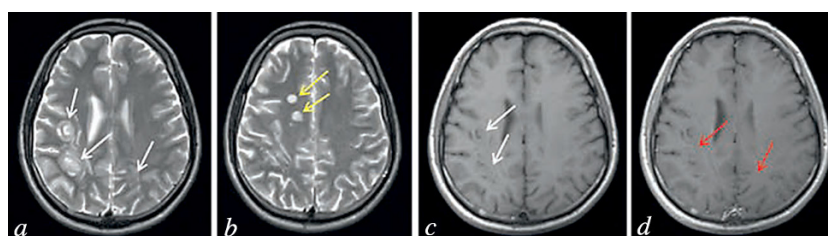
Brain MRI scan with contrast, March 21, 2016, T2 (a, b), T1 (c), and T1 modes after administration of contrast medium (d) modes, axial projection. The white matter of the frontal and parietal lobes of the right hemisphere of the brain and the parietal lobe of the left hemisphere of the brain contain three round plaques of heterogeneous structure (alternating annular zones reminiscent of annual growth rings in tree trunks) without perifocal changes (white arrows). Administration of contrast medium was not followed by its pathological accumulation (red arrows). In addition, the white matter of both hemispheres of the brain contain occasional typical plaques of demyelination (yellow arrows). Comparison of MRI brain scans demonstrated improvement, with decreases in the sizes of “annular” plaques, along with the absence of perifocal edema and pathological accumulation of contrast medium.
